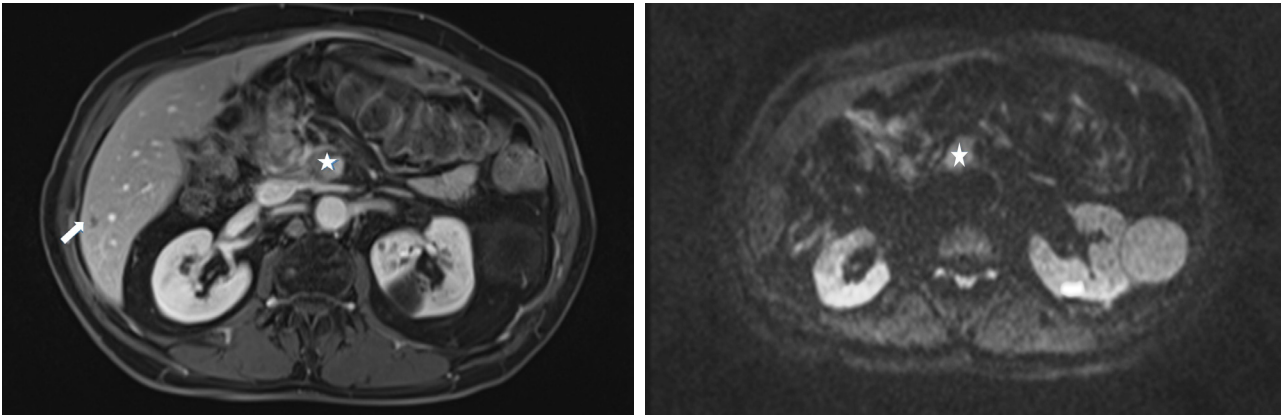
Fat suppressed contrast enhanced T1W MRI (left) shows tumour relapse in the perivascular area (asterisk) and a small lesion in liver segment VI (arrow). DWI (right) viewed on b 800 images, demonstrate tumour relapse (asterisk) and characterise better the liver lesion as a benign one.
